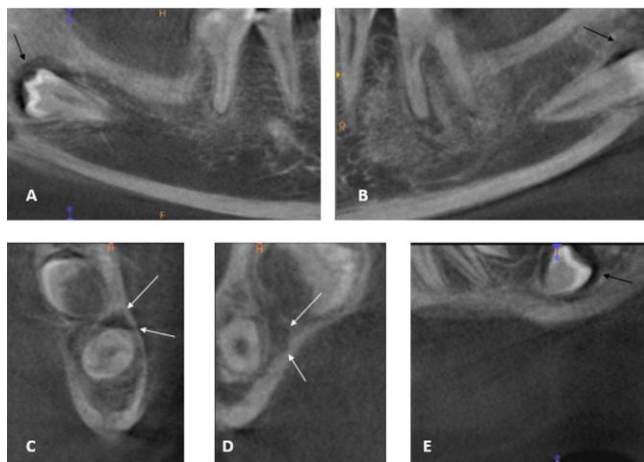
Coronal and sagittal CBCT images (A-E). Black arrows revealed the enlargement of follicular spaces (A, B, E). White arrows display inferior alveolar nerves (C, D).
